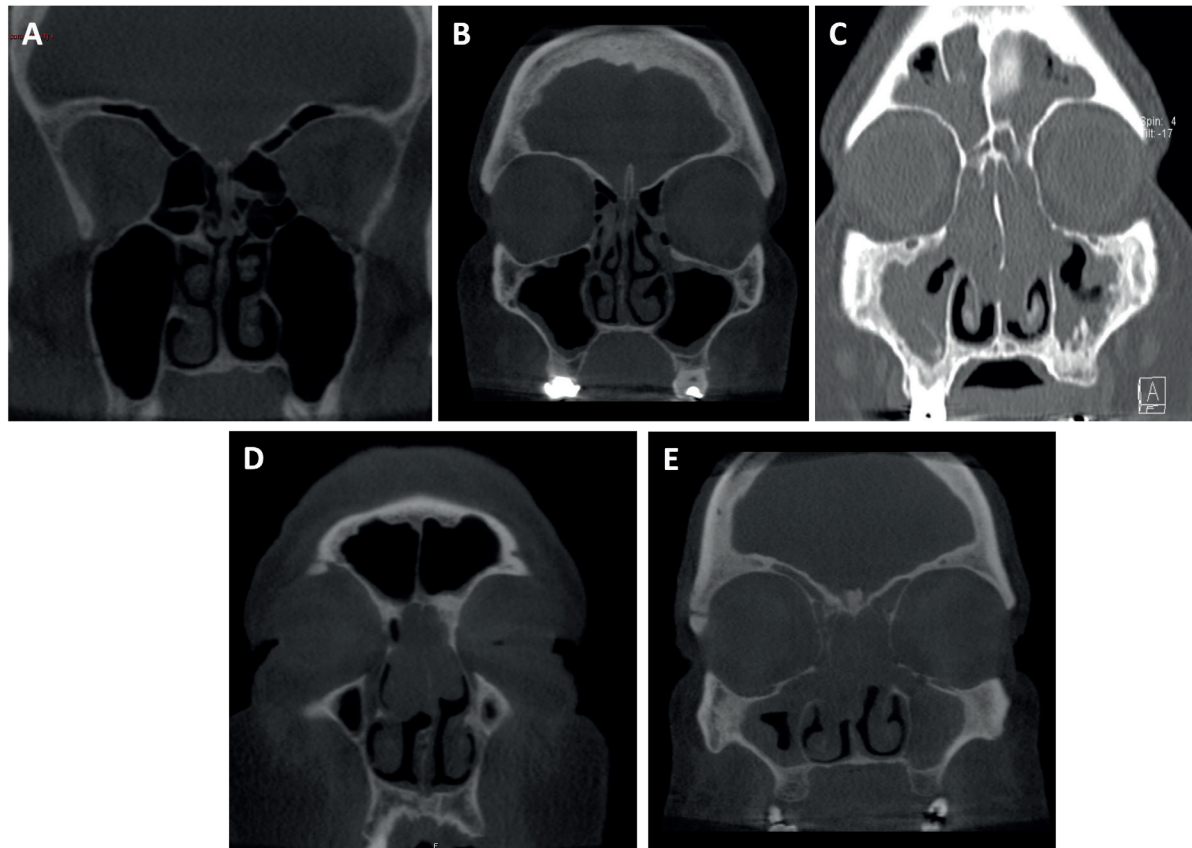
Coronal CT scans of patients with OC obstructions. A: OC syndrome, B: CRSsNP+OC, C: CRSwNP in OC, D: REAH, E: CRSwNP+REAH.
